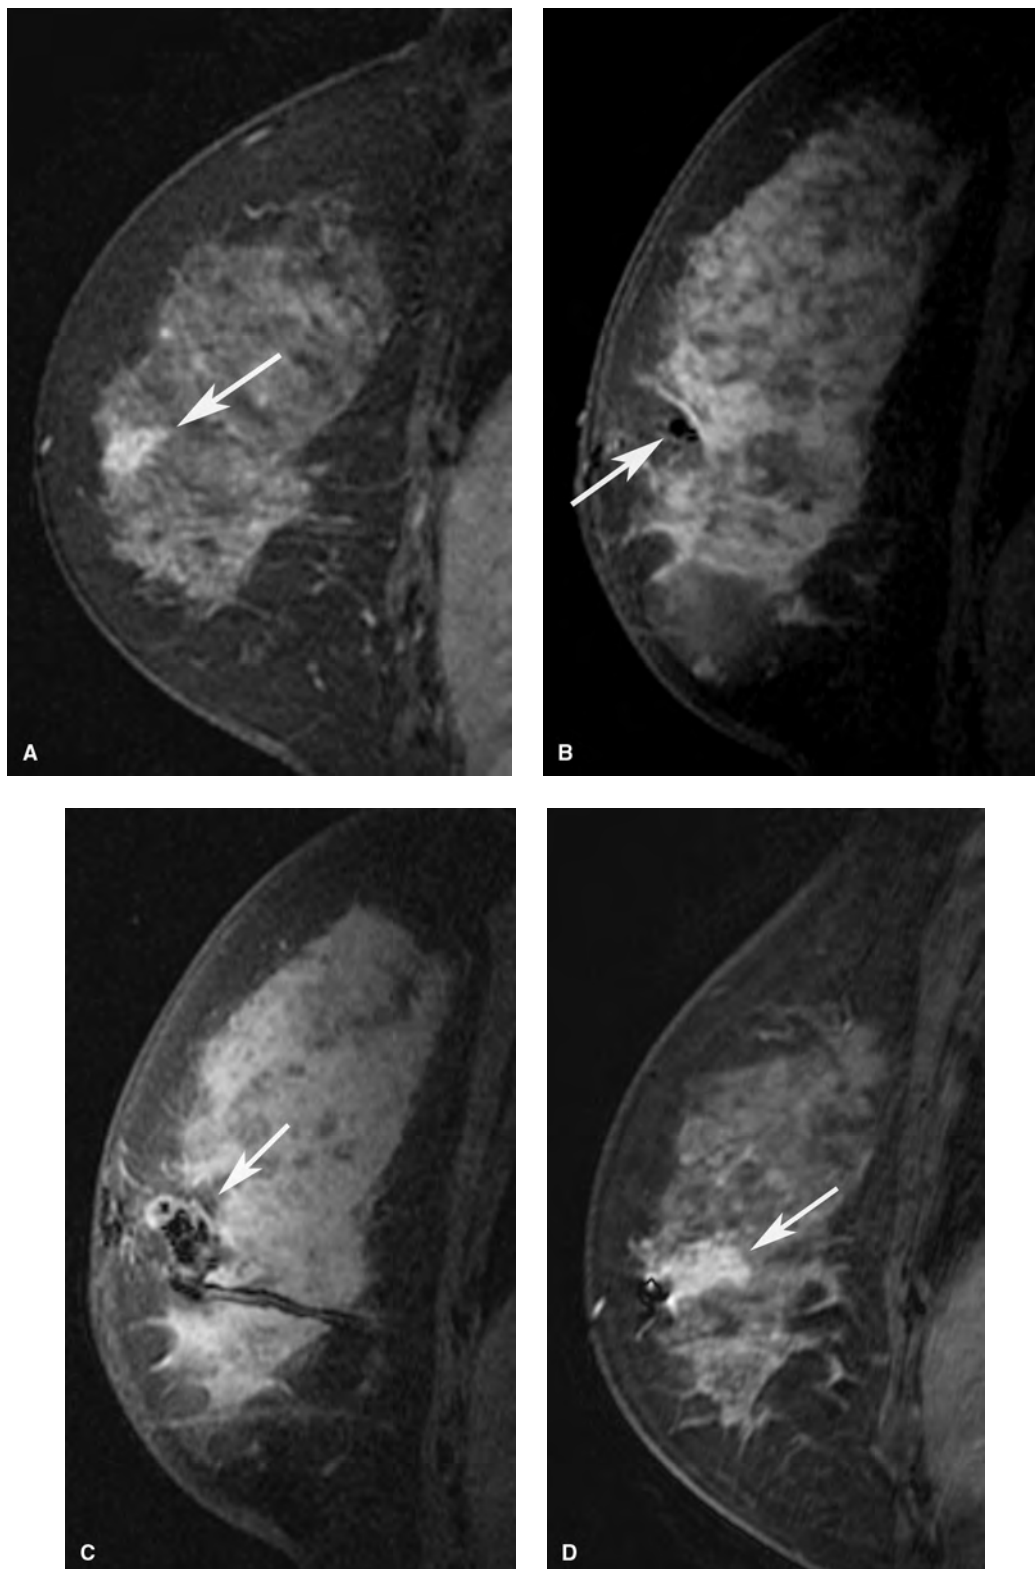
False negative MRI-guided biopsy. (A) Biopsy was recommended for an indeterminate area of nonmass enhancement (*arrow*) on screening breast MRI. (B) Sagittal fat saturated T1-weighted image demonstrates low signal from the obturator (*arrow*) at the anterior aspect of the nonmass enhancement that has become difficult to visualize. (C) Sagittal fat saturated T1-weighted image demonstrates expected postbiopsy changes (*arrow*) after sampling. Pathology-yielded stromal fibrosis, which was thought to be concordant. (D) Sagittal fat saturated T1-weighted image on the 6-month follow-up MRI demonstrates the localizing clip at the anterior aspect of the area of nonmass enhancement (*arrow*), which has now increased in size. Repeat MRI-guided biopsy yielded invasive ductal carcinoma.
